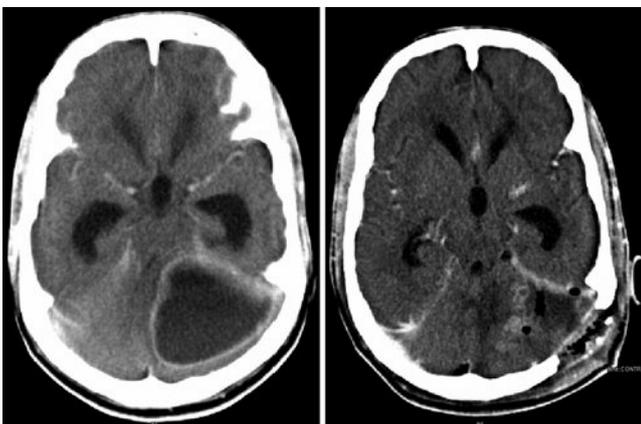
Contrast-enhanced CT scans obtained in a 12-year-old boy with left cerebellar abscess. A preoperative view (left) and postoperative view (right) demonstrating complete excision after craniectomy and excision.
